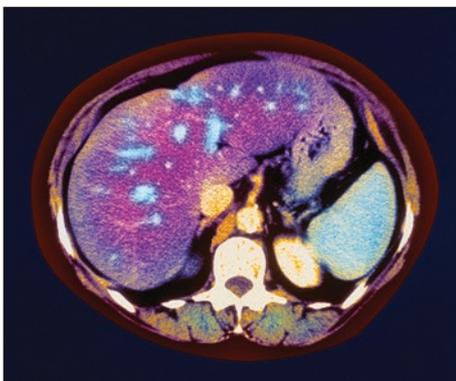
This is a coloured MRI scan of a person suffering from a fatty liver. The fat deposits can be seen as blue patches in the liver (purple).
